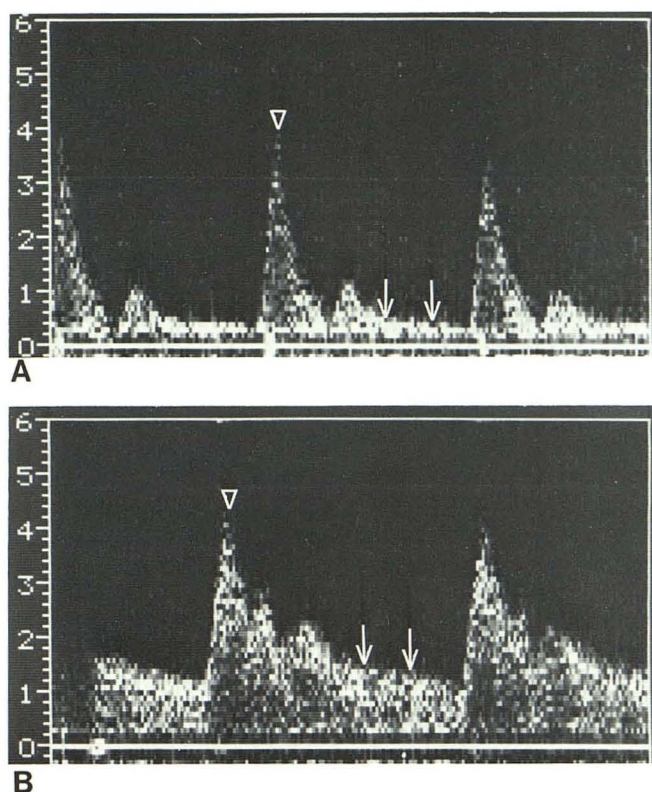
Comparison of sonograms in normal external (A) and internal (B) carotid. Prominent systolic component (arrowheads) and relative lack of diastolic flow (arrows) in external compared with internal carotid. These differences are readily appreciated in audible Doppler signals.
